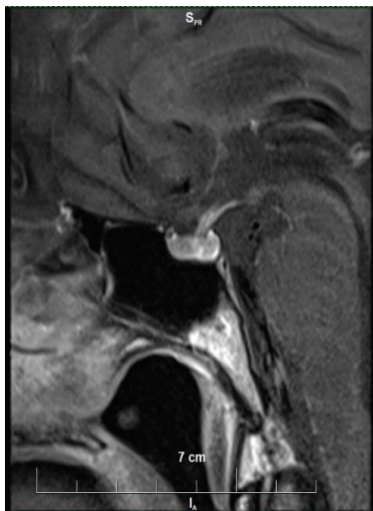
Magnetic resonance imaging of the pituitary gland with evidence of hypophysitis
